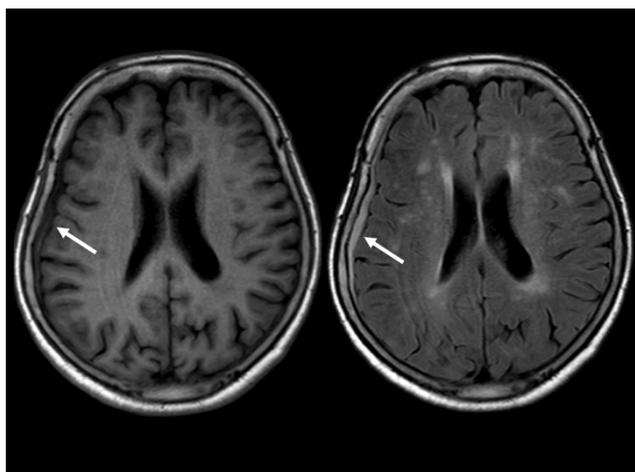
Magnetic resonance imaging (MRI) on arrival. MRI showed iso-intensity on T1-weighted imaging (left) and high-intensity acute subdural hematoma on fluid-attenuated inversion recovery imaging (right)
